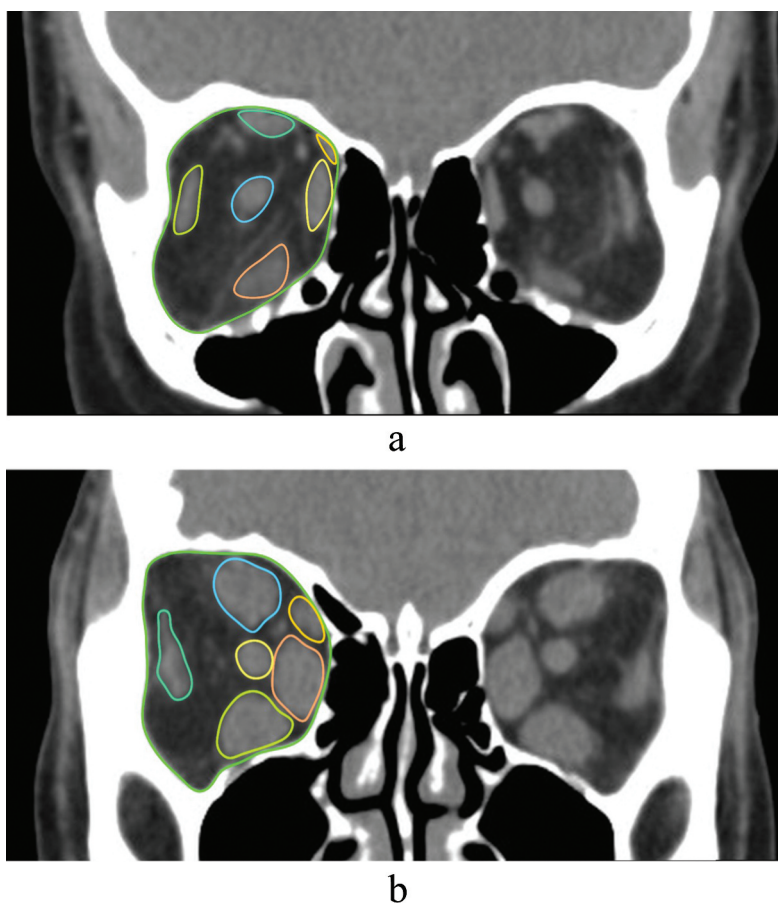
(a) Coronal CT of a patient with a high FMR showing manual segmentation of the right intraorbital contents. (b) Coronal CT of a patient with a low FMR showing manual segmentation of the right intraorbital contents.
